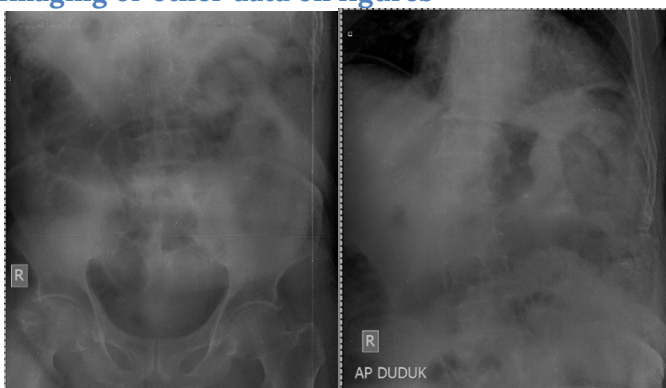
Abdominal Three Position X-ray Evaluation (Upright abdominal X-ray demonstrated free subdiaphragmatic air, while the left-lateral decubitus view showed a distinct radiolucent crescent outlining the lateral liver edge and rising between the liver and the right abdominal wall, findings highly suggestive of a gastrointestinal perforation)
